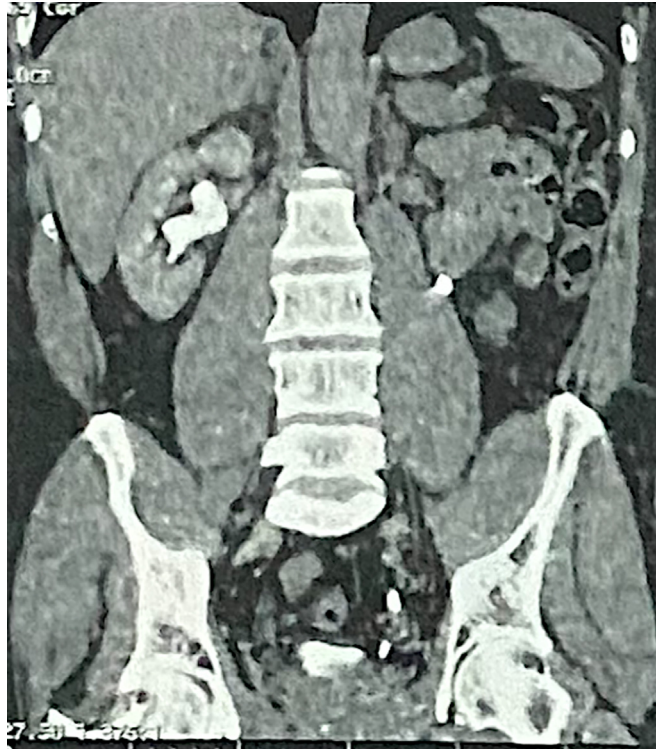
Coronal plane of a CT scan showing a right hydronephrosis secondary to a compression or invasion of the ureter by the tumor.
